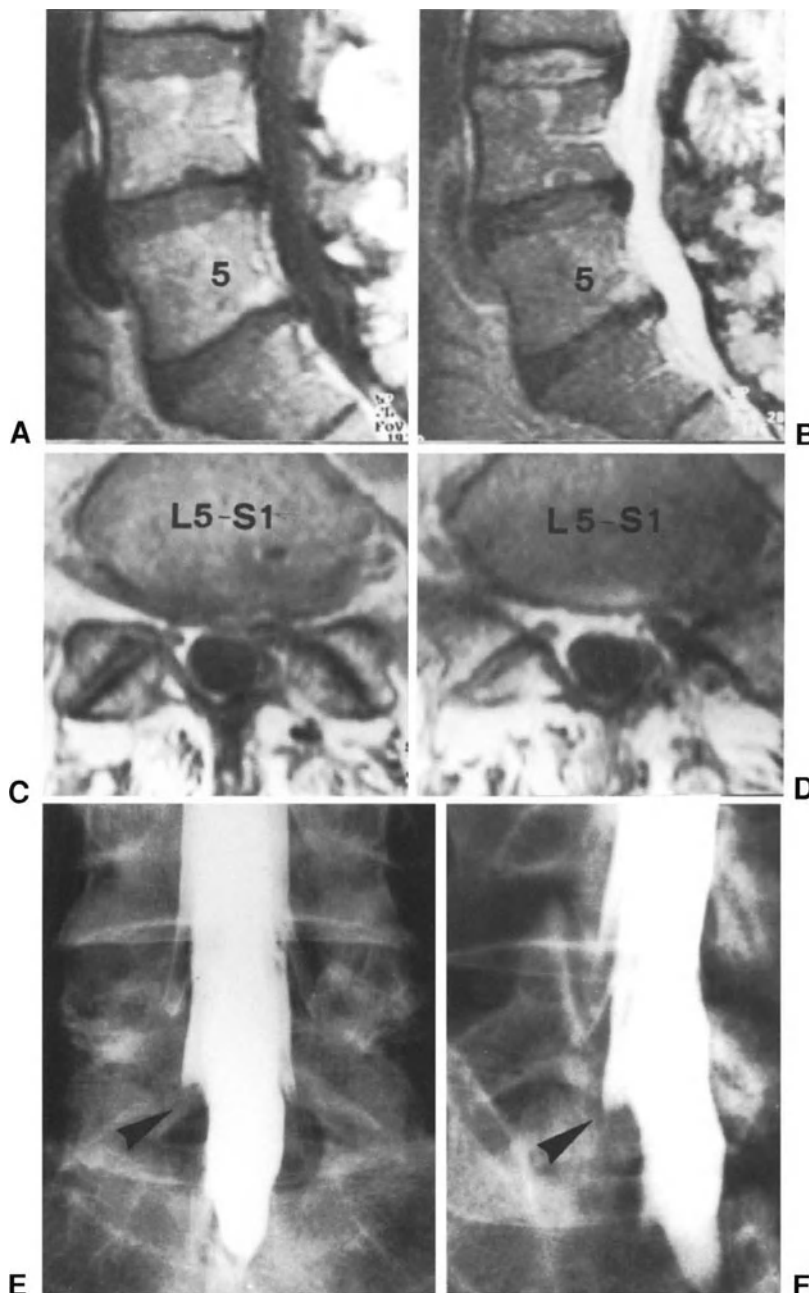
This 62-year-old male had undergone excision of L5-S1 disc herniation on the left in 1982 and ipsilateral L4-L5 intraforaminal herniation in 1994. In 1996, sciatic pain, not associated with low back pain, appeared quite suddenly on the right side. The pain, extremely severe, was located in the S1 dermatome, but particularly in the buttock and thigh. Physical examination revealed limitation of SLR at 60° and bilateral absence of the ankle jerk, but no loss of power of the triceps surae. Corticosteroids were administered for 1 week. The severity of the pain, however, led to the need for CT, which did not reveal any pathologic condition on the right side. After 4 days, the patient was admitted to our hospital due to persistence of severe pain, despite high doses of analgesics. MRI revealed mild annular bulging at the two lowermost lumbar levels on T1- and T2-weighted sagittal images (A) and (B) and abnormalities resulting from the previous surgical treatments on the right side on T1-weighted axial scans; at L5-S1 level, axial sections (C) and (D) showed no significant pathologic conditions on the right. After 2 days, myelography (E) and (F) was performed, which showed non-filling of the right S1 nerve-root sleeve (arrowhead). At surgery, a small contained L5-S1 disc herniation and slight S1 nerve-root canal stenosis was found on the right. Soon after surgery, the radicular symptoms disappeared almost completely. The result was satisfactory at the 3-month follow-up evaluation.
